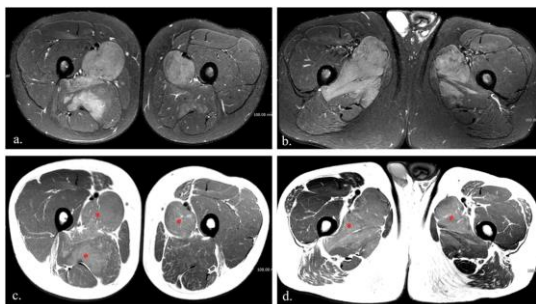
19-year-old patient axial fast-STIR (a,b) show an asymmetric involvement of the adductors and posterior compartment muscles of the thighs. In axial T1-weighted FSE (c,d) a mild hyperintensity (red asterisks) of non fat-infiltrated muscles, exactly matching to STIR MRI pattern, is detected.
